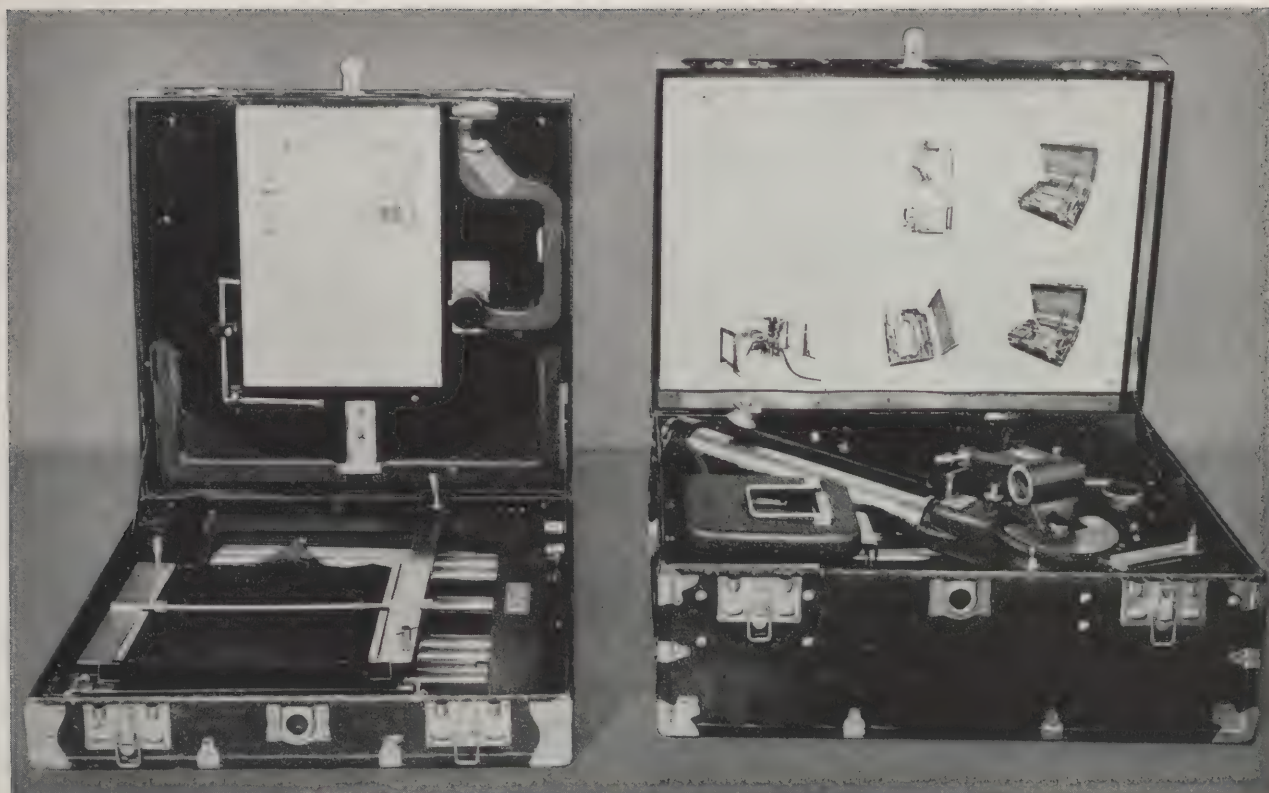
Item 96145, field X-ray table. Packed in chests.
